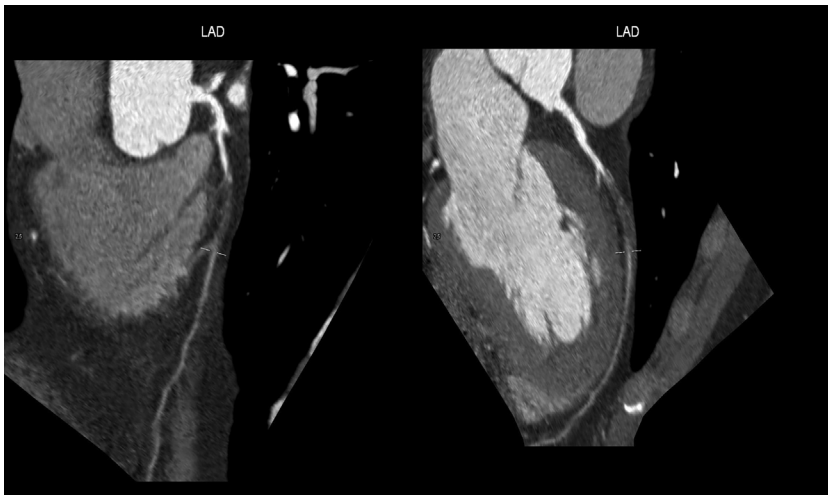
Cardiac computed tomography: a severe left anterior descending artery stenosis.
